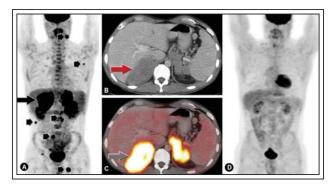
Coronal PET MIP image (a) shows the adrenal masses (long arrow) with intense FDG activity. Also note multiple small hypermetabolic lesions (short arrows) corresponding to additional malignant lesions, mostly lymph nodes, not identified on the MRI. Corresponding axial contrast enhanced CT (b) and axial fused PET/CT (c) shows the adrenal masses to be hypoattenuating with mild enhancement. Post treatment scan (d) shows complete metabolic response with resolution of abnormal metabolic activity within all of the previously identified lesions.
